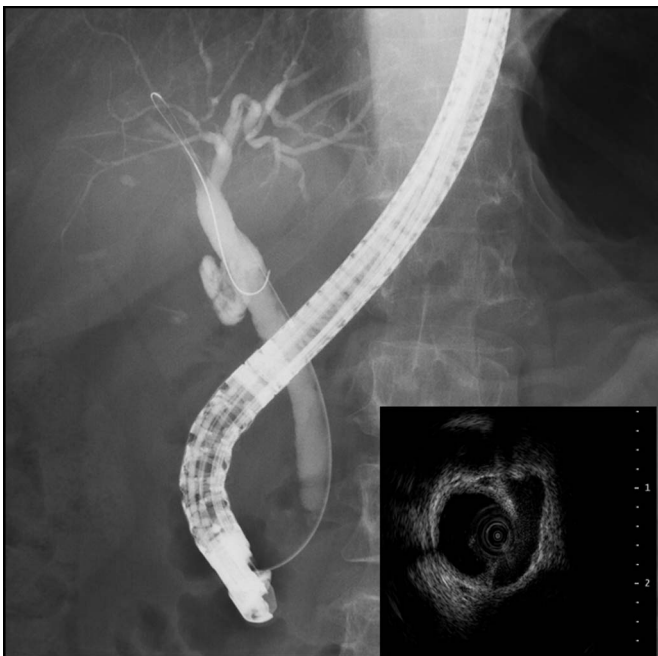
Endoscopic retrograde cholangiography demonstrating no biliary abnormalities. Intraductal ultrasound indicated uniform wall thickening toward the papilla from the hilar, but no biliary pancreatic duct confluence abnormalities.
